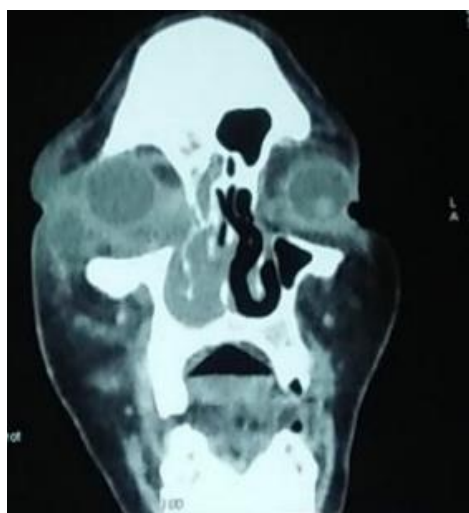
Facial CT scan: infiltration of the orbital cavity, the nasal cavity and the right ethmoidal sinus.
